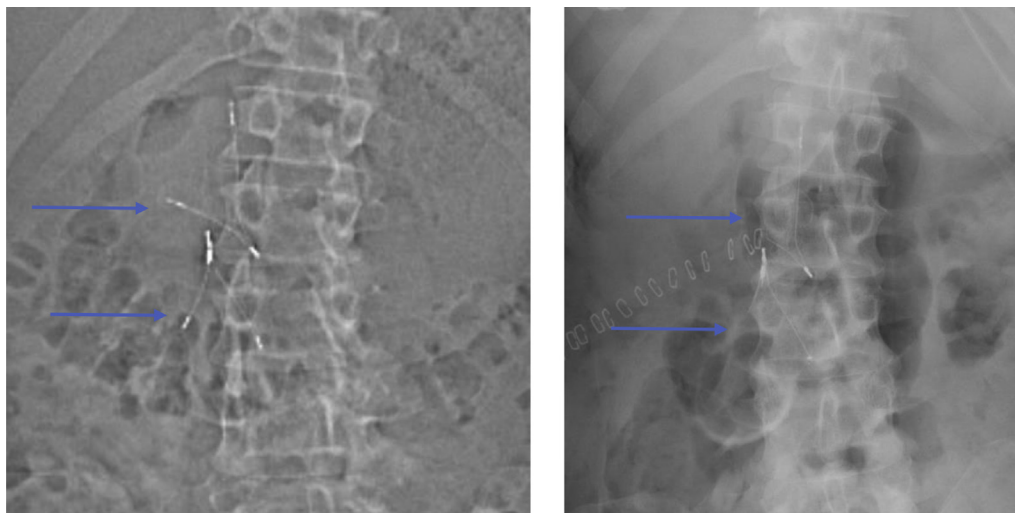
Removal of Bird's Eye filter struts. An abdominal X ray taken the day before discharge (right) showed a smaller length of struts secondary to surgical removal when compared with scout film from computed tomography on admission (left).
